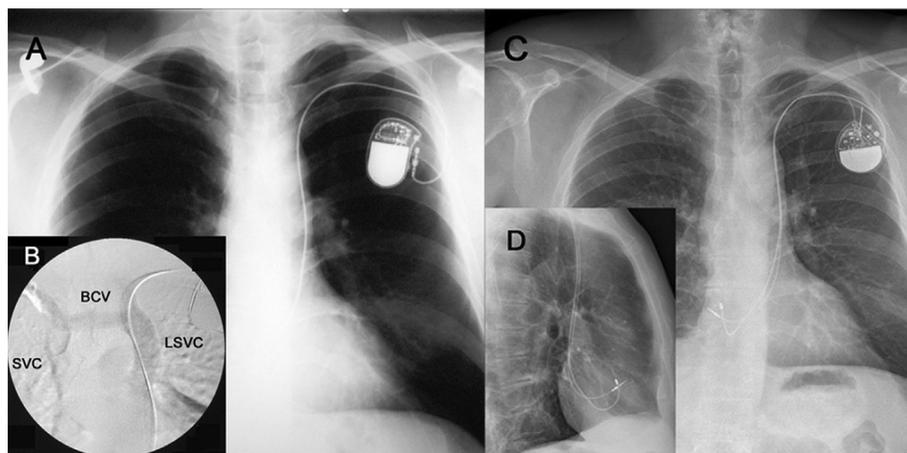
(A, B, C, D). Case 1. (A) Chest X-ray, posterior-anterior (PA) view, showing the atrial lead implanted in September 2003; (B) Venography showing contrast flow through both SVCs and the BCV connecting them (2003); (C, D) An X-ray film (January 2013) also showing the new lead implanted in May 2006, in (C) PA and (D) lateral views.
